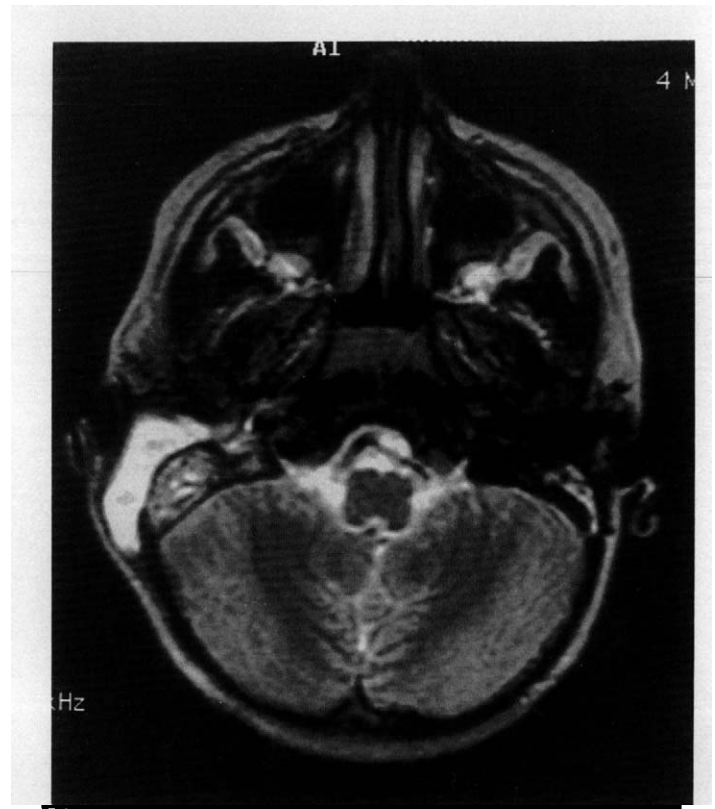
Transverse T₂-weighted MRI shows thrombosis of the right sigmoid/transverse sinus in a 5-year-old boy with mastoiditis. There is no evidence of hemorrhagic or ischemic stroke.
